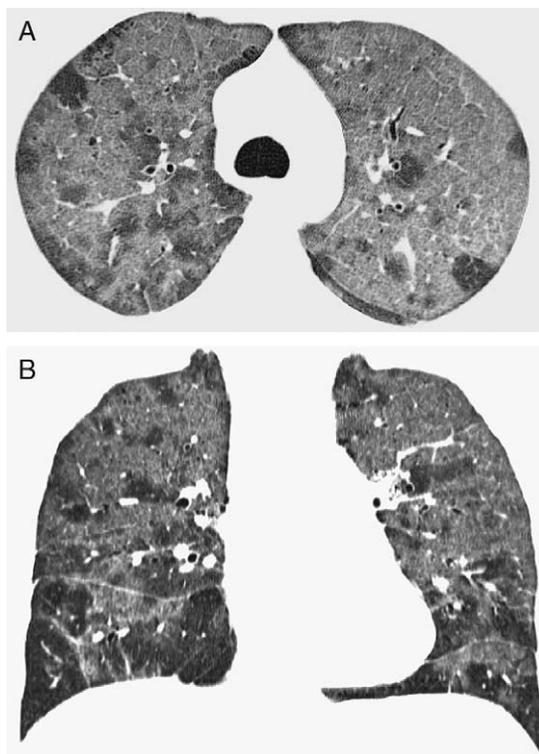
A 36-year-old male HIV-positive intravenous drug user with *Pneumocystis* pneumonia. A, High-resolution CT image obtained on a multidetector CT scanner demonstrates extensive bilateral ground-glass opacities. Several pulmonary lobules seem normal or have mild abnormalities resulting in an inhomogeneous appearance of the lungs. B, Coronal image better demonstrates the overall distribution of the ground-glass opacities.
